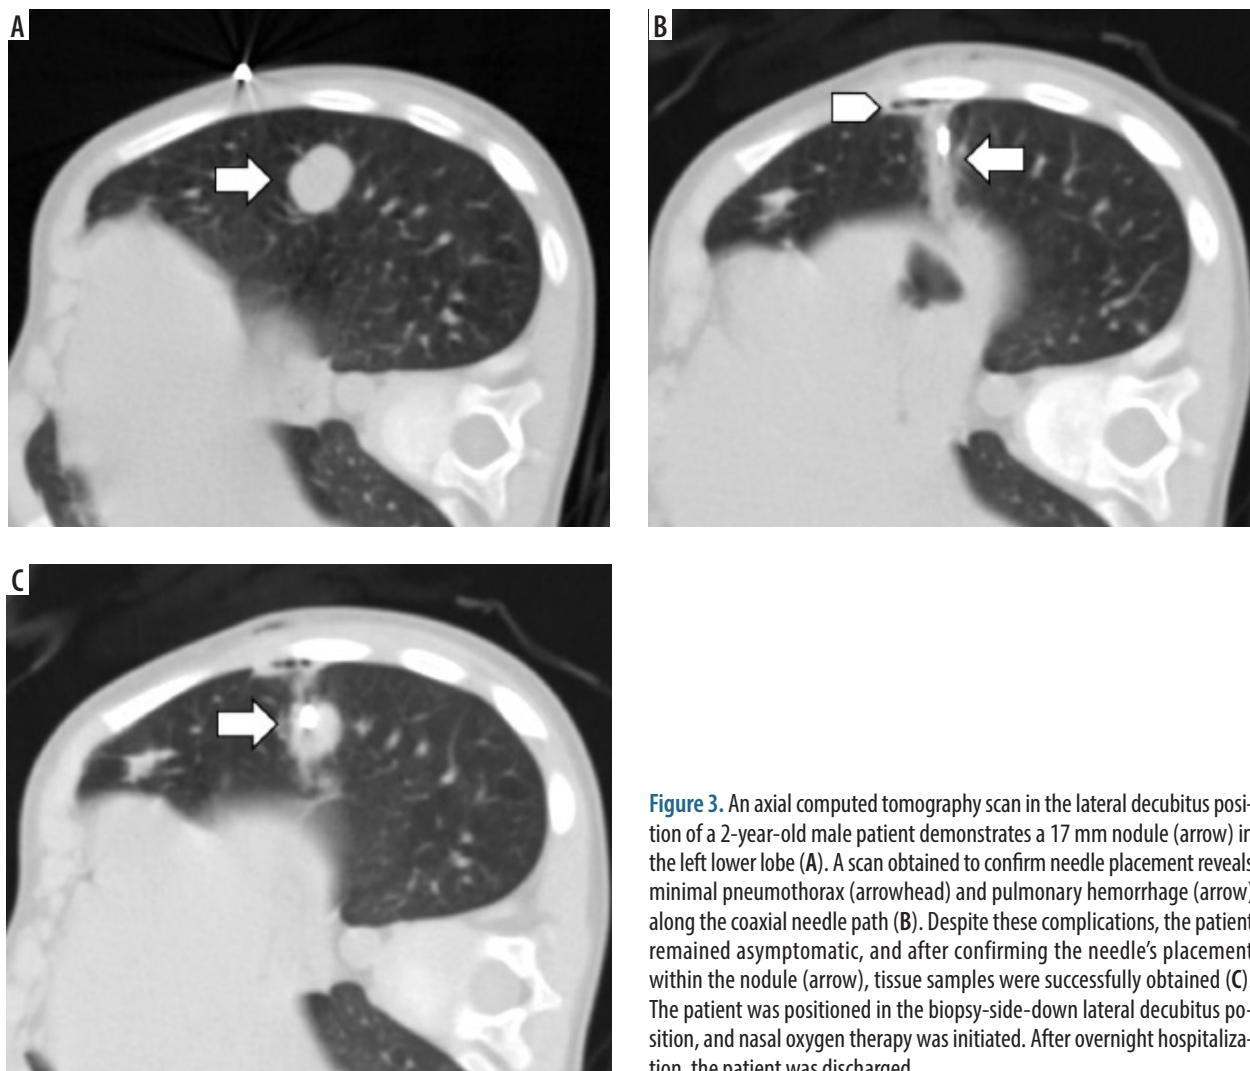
An axial computed tomography scan in the lateral decubitus position of a 2-year-old male patient demonstrates a 17 mm nodule (arrow) in the left lower lobe (A). A scan obtained to confirm needle placement reveals minimal pneumothorax (arrowhead) and pulmonary hemorrhage (arrow) along the coaxial needle path (B). Despite these complications, the patient remained asymptomatic, and after confirming the needle's placement within the nodule (arrow), tissue samples were successfully obtained (C). The patient was positioned in the biopsy-side-down lateral decubitus position, and nasal oxygen therapy was initiated. After overnight hospitalization, the patient was discharged
